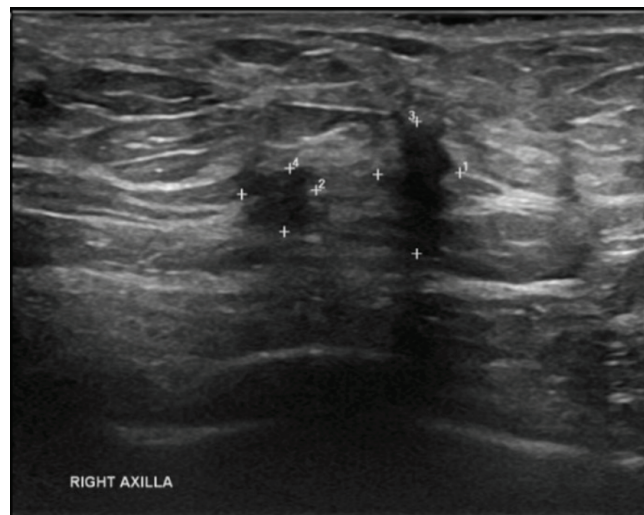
Ultrasonography showing two, ill-defined, hypoechoic, solid masses
